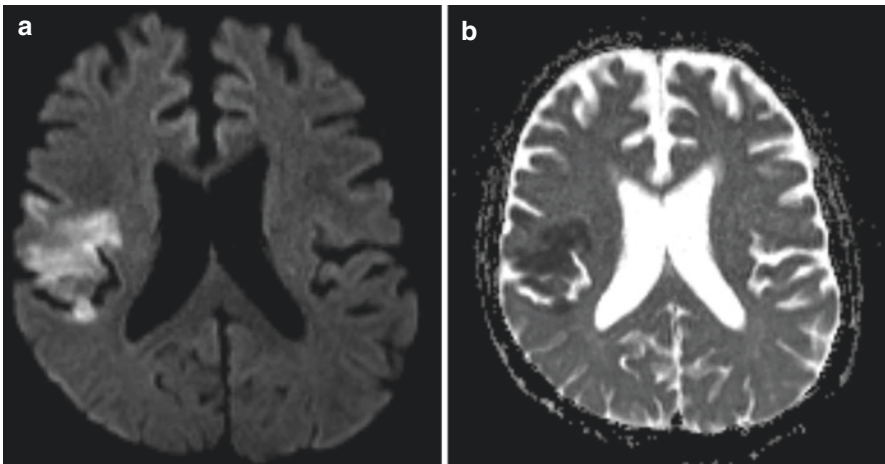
Depicting the DWI and the ADC images of an early stage infarct. (a) Magnetic resonance (MR) axial images showing patchy zones bright on DWI suggesting early stage infarct. (b) MR axial images showing patchy dark zones on ADC suggesting early stage (hyperacute) infarct
